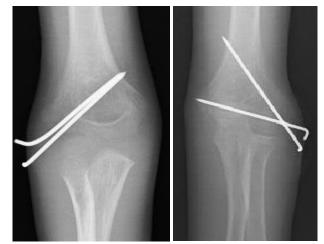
Postoperative radiographic image of Figure 3: Postoperative radiographic image a patient who underwent the parallel K-wire of a patient who underwent the divergent K-method wire method
